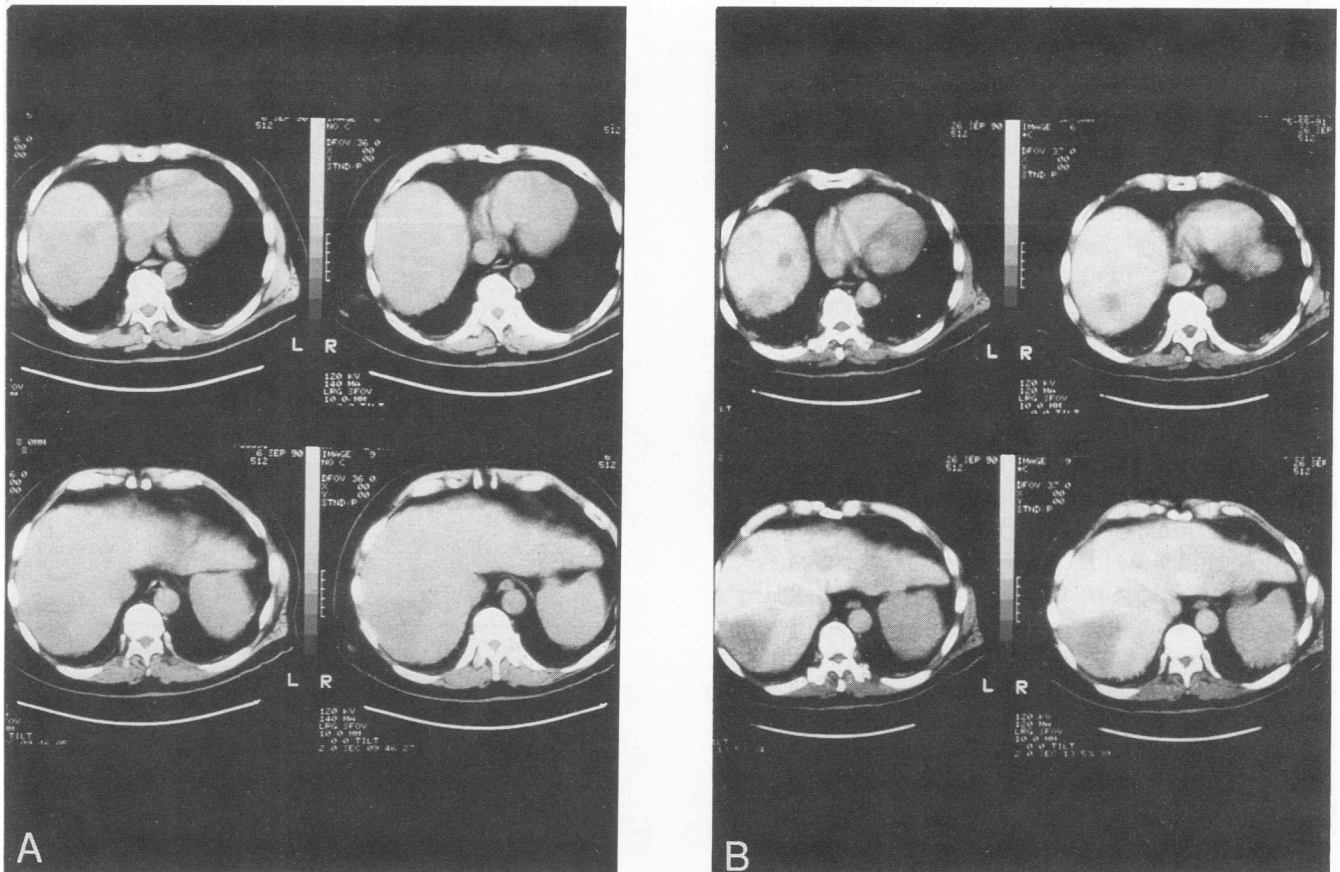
(A) Standard infusion enhanced CT demonstrating a large (but diffuse) right posterior lesion. There is a suggestion of dome lesions on the right. (B) Computed tomographic arterial portography accurately delineates numerous lesions in the right posterior, right dome, and left medial segments of the liver. There also is a suggestion of metastatic lesions in the left lateral segment.
